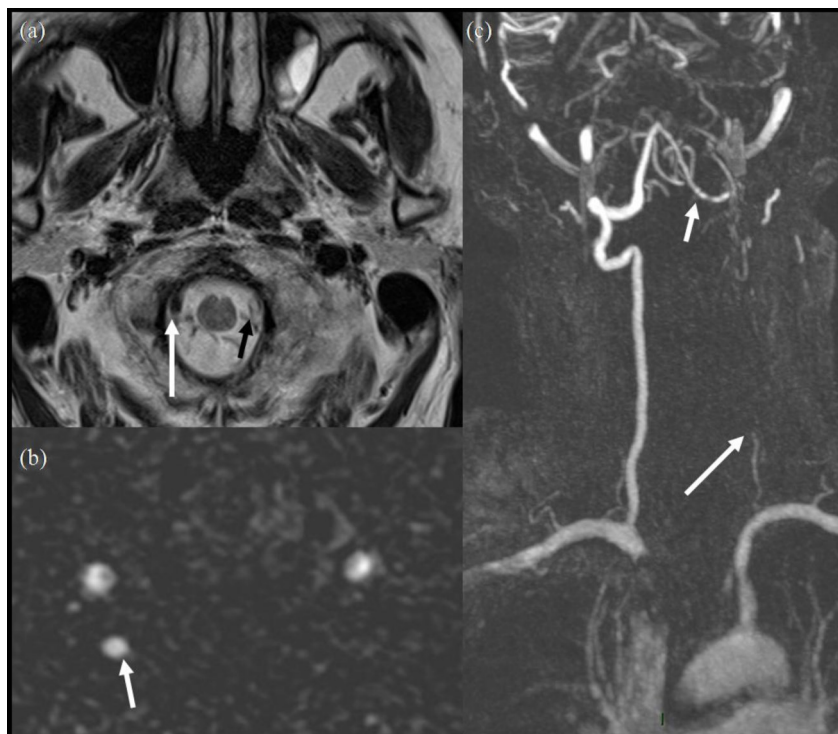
Initial MRI. T2 axials (a) showing normal right vertebral artery (white arrow) and abnormal signal in the left vertebral artery (black arrow). Axial MRA reconstructions (b) show normal right vertebral artery (white arrow) while the left vertebral artery is missing. Maximum Intensity Projection (MIP) images of MRA (c) show a barely identified V1 segment of left vertebral artery (long white arrow) and an abnormal and irregular V4 segment of left vertebral artery (short white arrow).
